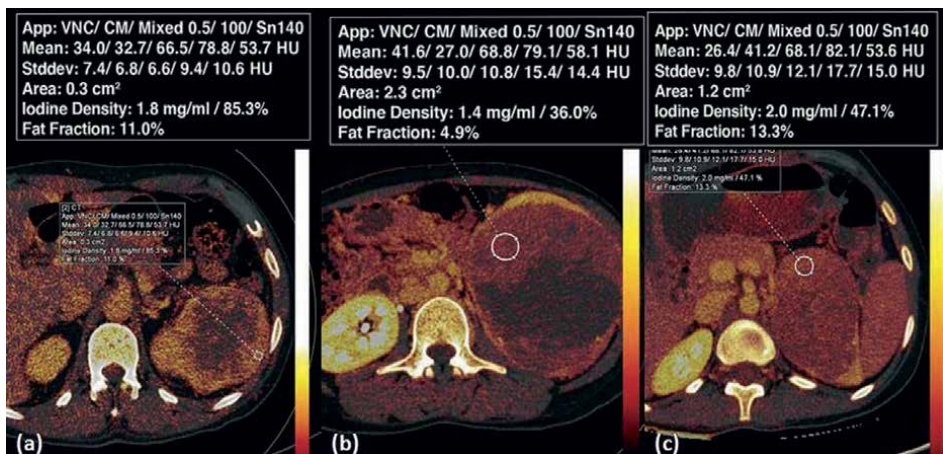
Axial section of dual energy CT scan (DECT) image showing ccRCC, papillary RCC and Chromophobe RCC in left kidneys of three different patients. Iodine ratio (appears as iodine density in images) is 85.3% in ccRCC, 36% in papillary RCC and 47.1% in Chromophobe RCC. Circles denotes the region of interest in tumors [21].
